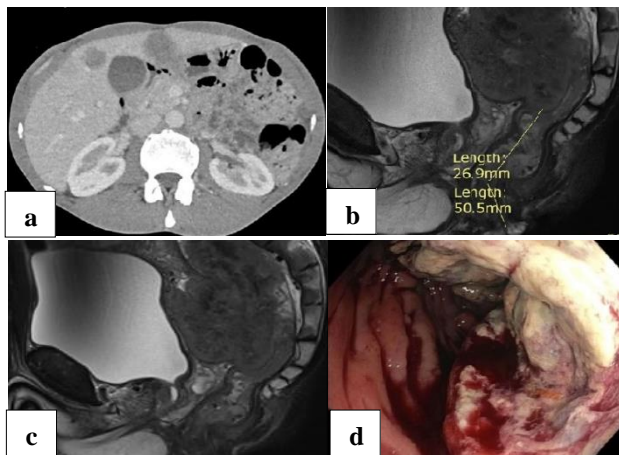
(a) CT abdomen at the time of presentation, (b) and (c) MRI rectum, and (d) flexible sigmoidoscopy showing fungating mass in mid-rectum.
